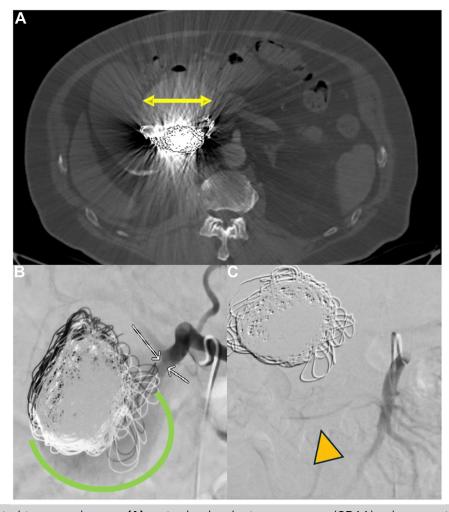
Computed tomography scan (A) gastroduodenal artery aneurysm (GDAA) enlargement (*yellow arrow*) beyond placed coils and diagnostic angiogram revealing (B) flow through aneurysm sac (*green arch*) (C) and lack of perfusion source from pancreaticoduodenal and right gastroepiploic arteries (*orange arrowhead*).
